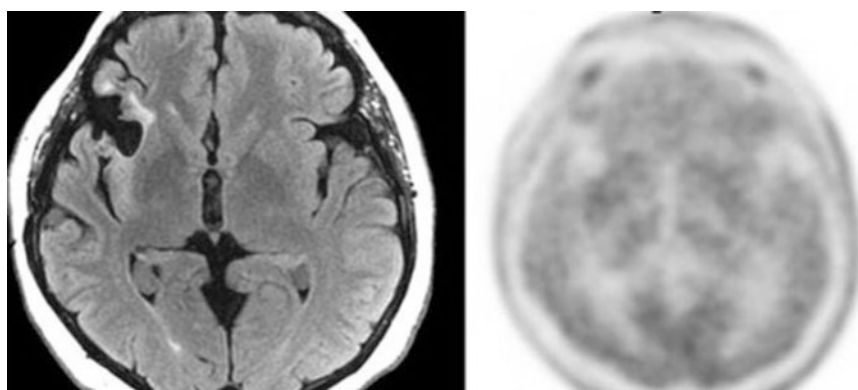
Example of no pathologic uptake of ^{11}C -Methionine (right-sided view) in the suspected right fronto-temporal lesion described at T1 weighted MRI (left-sided view)
